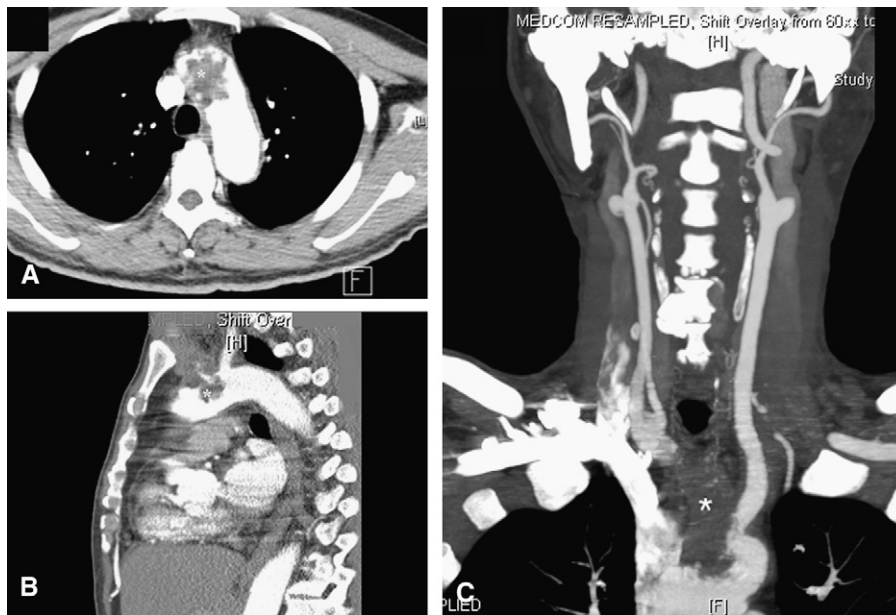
Preoperative chest computed tomographic angiogram. A, *Horizontal view*: an unusual mass in the ascending aorta and aortic arch. B, *Sagittal view*: floating, cauliflower-like mass at the orifice of the left common carotid artery. C, *Coronary view*: complete obstruction of the innominate artery and compromise of the left common carotid artery orifice. Asterisk, Intra-aortic mass.
